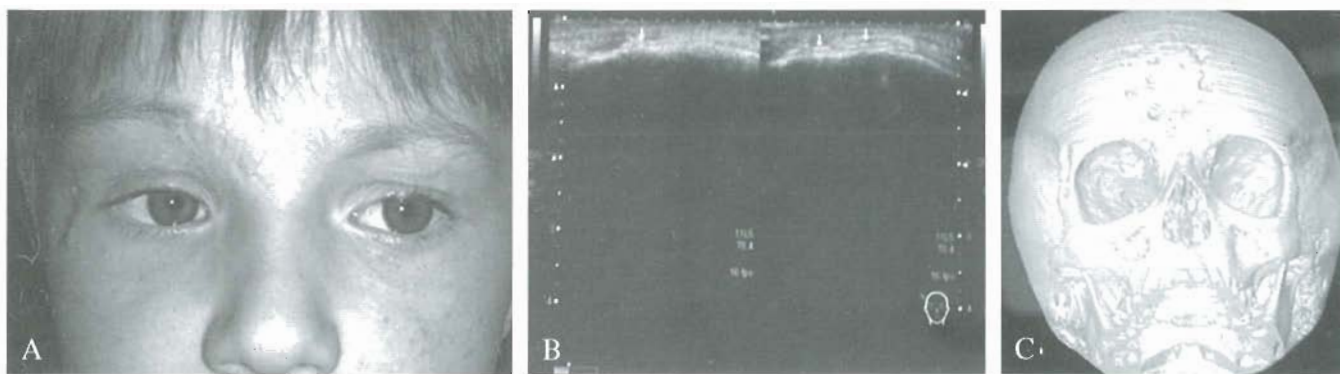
Clinical (A), ultrasonography (B) and CT (C) follow-up 6 months after surgery.
